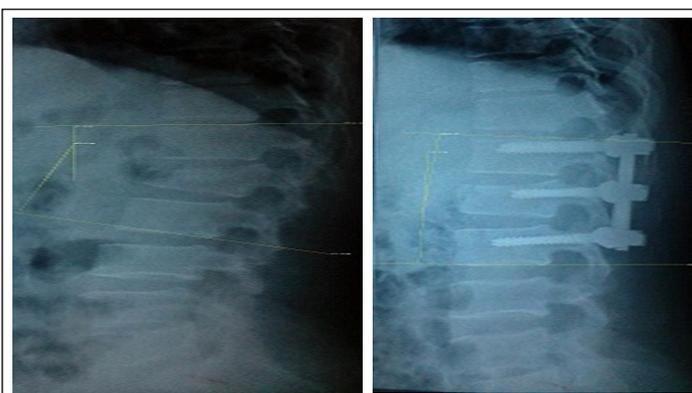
Radiograph images demonstrating degree of kyphosis
